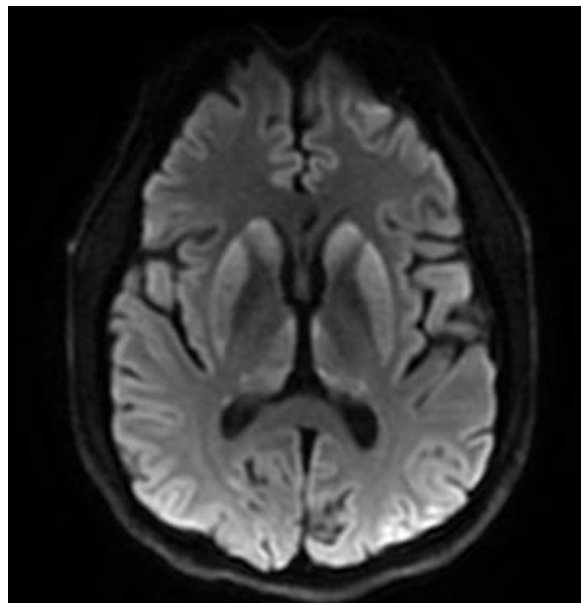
MRI brain without contrast obtained during admission reveals bilateral symmetric caudate and lenticular nuclei hyperintensity in FLAIR sequence. There is bilateral pulvinar and medial thalamus hyperintensity producing a hockey-stick pattern.
